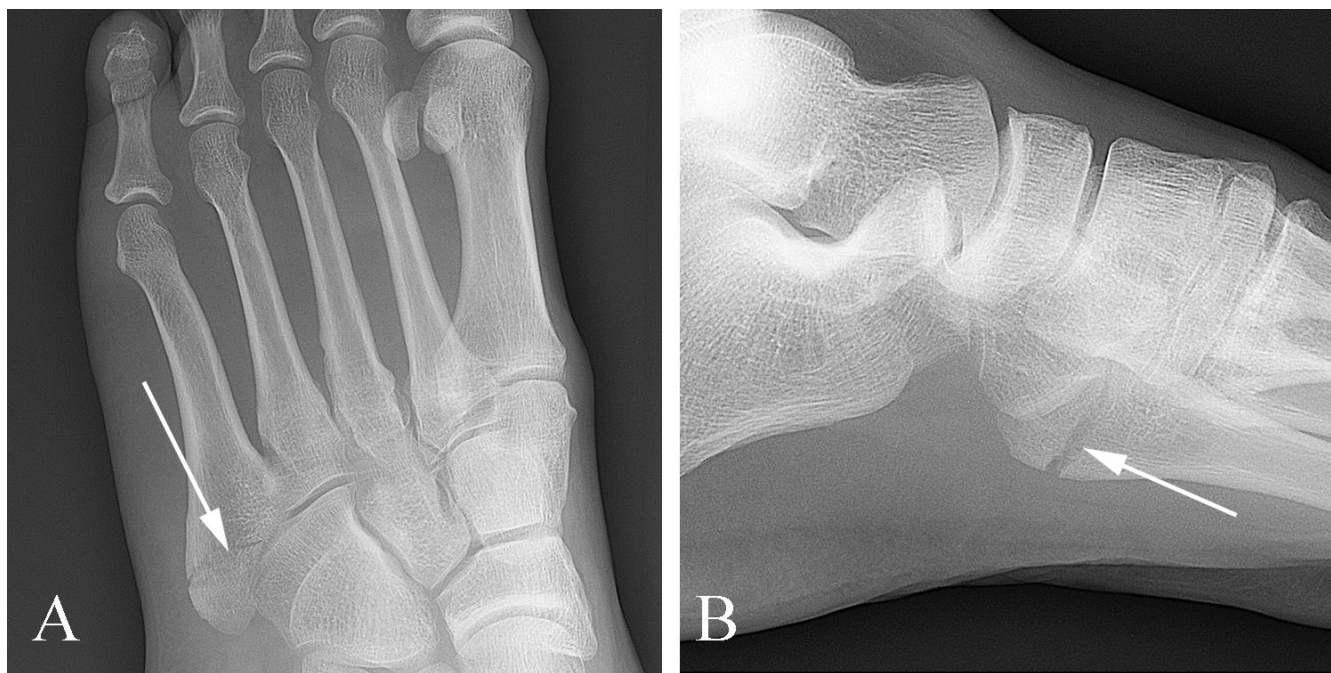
Fracture of the proximal aspect of the small toe metatarsal in a 57 year old man with acute foot pain following trauma. A. Oblique plain film of the foot demonstrates fracture lucency (arrow) through the base of the small toe metatarsal. B. Lateral examination also demonstrates the fracture lucency (arrow) along the base of the small toe metatarsal.
